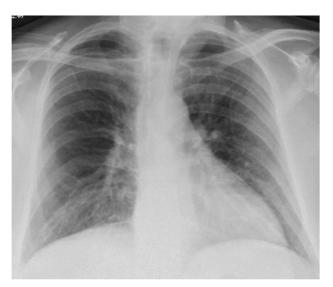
Chest radiograph before liver transplantation.
